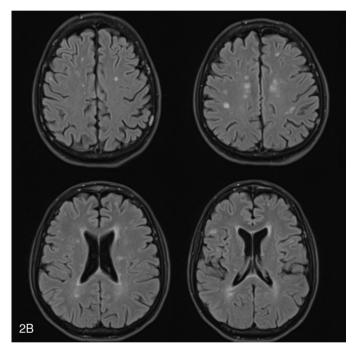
MRI findings of the patient
